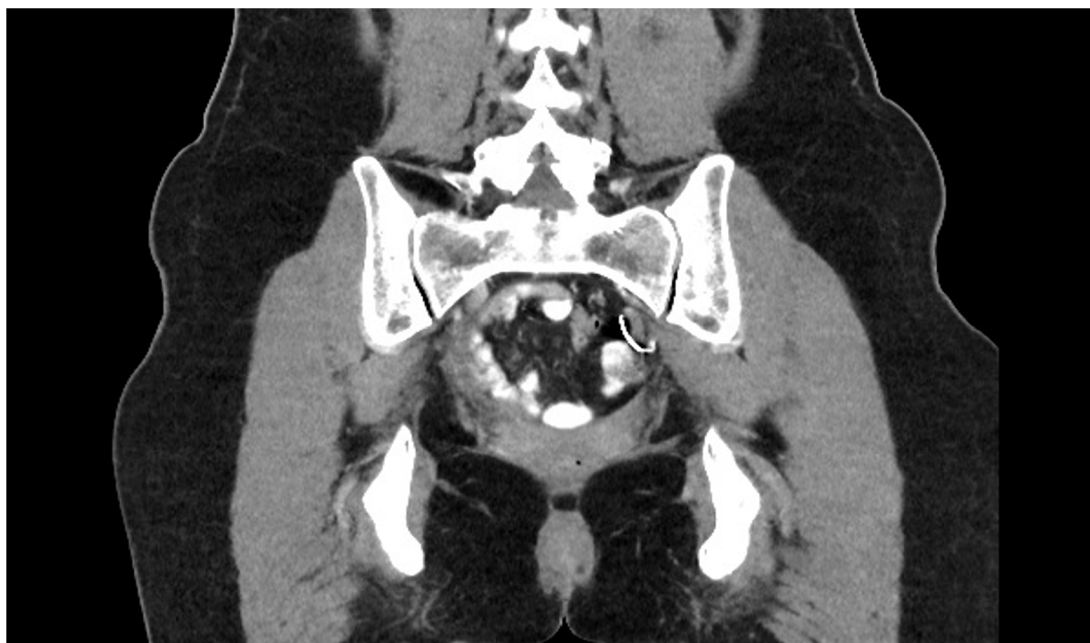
Computed Tomography abdomen-pelvis reveals evidence of hysterectomy and a curvilinear metallic density structure in the left hemipelvis.
